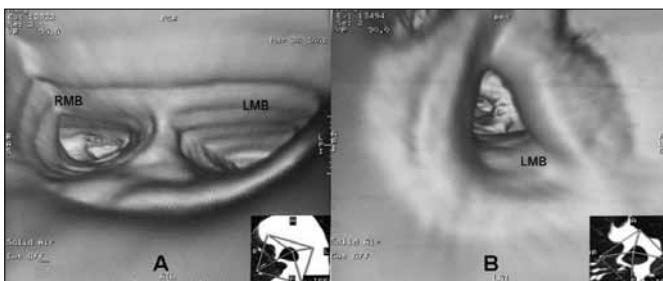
Images from the same level, acquired by virtual CT
